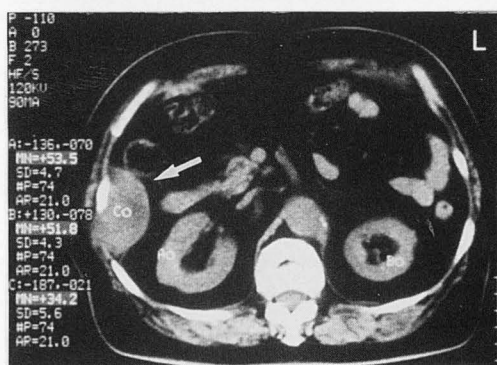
Abdominal computed tomography. Lesion 6.0×5.0cm in size with uniform low density and smooth surface is seen to involve the rib and develop into the intraabdominal cavity.
